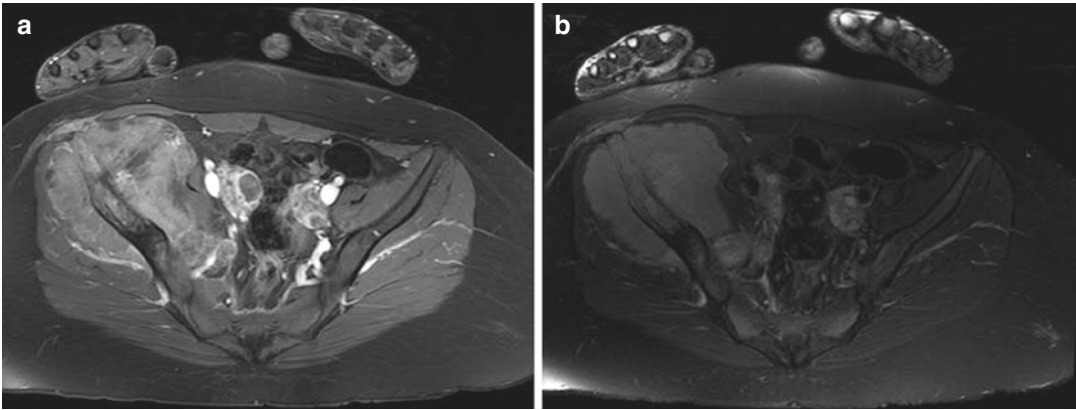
(a) Prechemotherapy, post-gadolinium T1 axial MRI of a pelvis Ewing sarcoma. (b) Prechemotherapy, T2 axial MRI of a pelvis Ewing sarcoma
